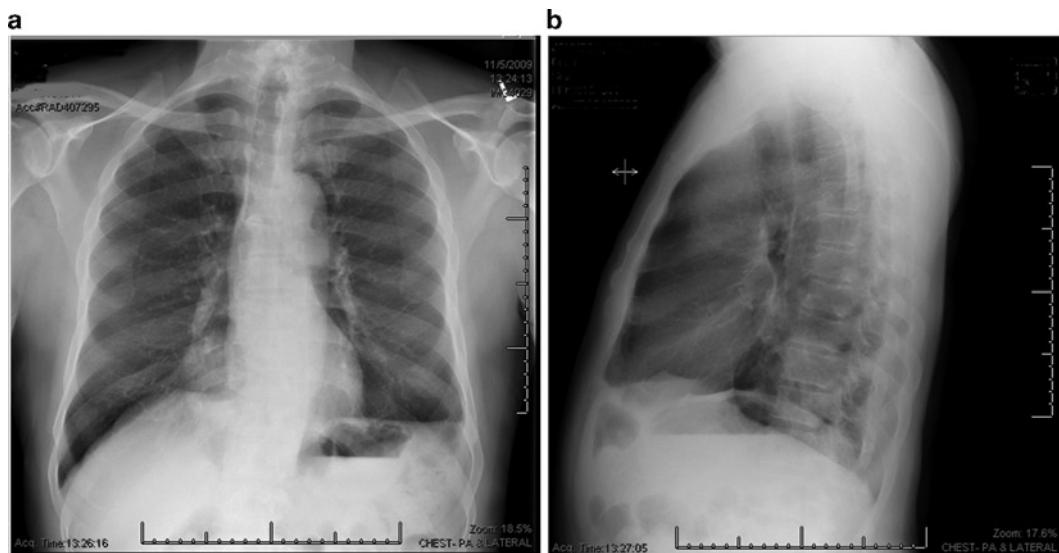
(a) A posteroanterior chest radiograph of a 68-year-old male with a lung neoplasm of the right lower lobe. The mass is clearly visible between the eighth and ninth rib in the right hemithorax. (b) A lateral chest radiograph showing a round mass in the right hemithorax.
